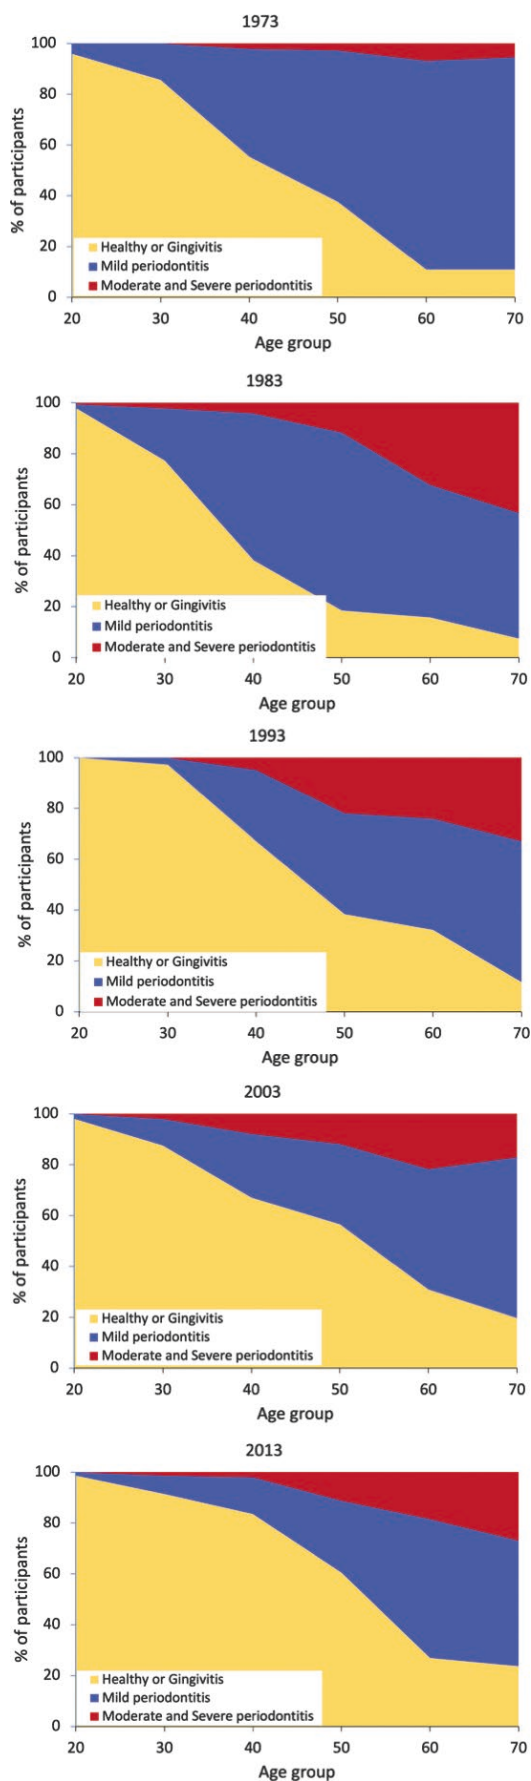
The results of five repeated cross-sectional studies of periodontal diseases among adults from Jönköping, Sweden [98, 99]. At each survey, approximately 100 adults aged 20, 30, 40, 50, 60, and 70 years were examined clinically and radiographically and classified according to periodontal disease severity. Healthy, bleeding on gentle probing in  $< 20\%$  of sites; gingivitis, bleeding on gentle probing in  $\geq 20\%$  of sites, normal alveolar bone height; mild periodontitis, alveolar bone loss predominantly  $< \frac{1}{3}$  of the root length; moderate periodontitis, alveolar bone loss predominantly between  $\frac{1}{3}$  and  $\frac{2}{3}$  of the root length; severe periodontitis, alveolar bone loss predominantly  $> \frac{2}{3}$  of the root length, including angular bony defects and furcation defects
